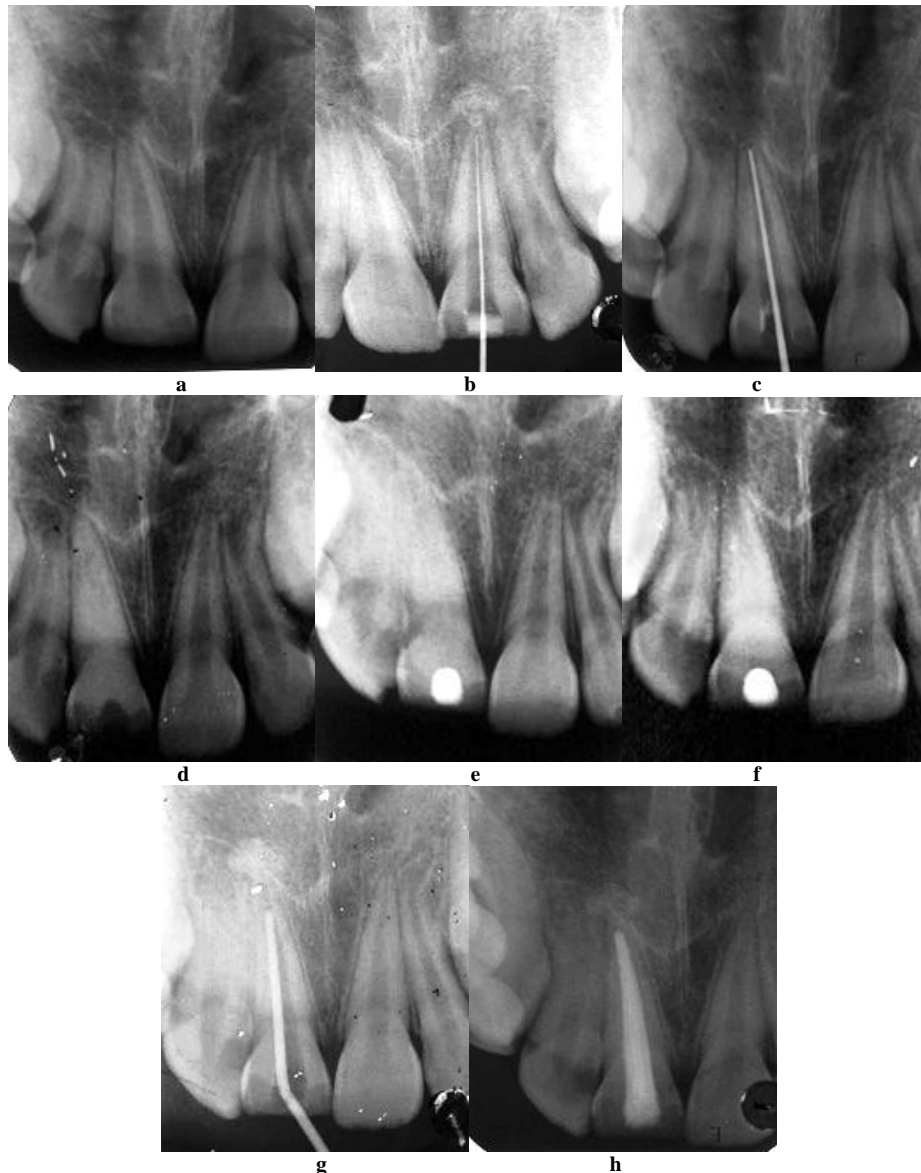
Apexification in 11 completed in 5 months: (a) pre-operative radiograph; (b) working length determined; (d) calcium hydroxide paste placed in the canal; (e) & (f) access cavity restored with glass ionomer cement.
